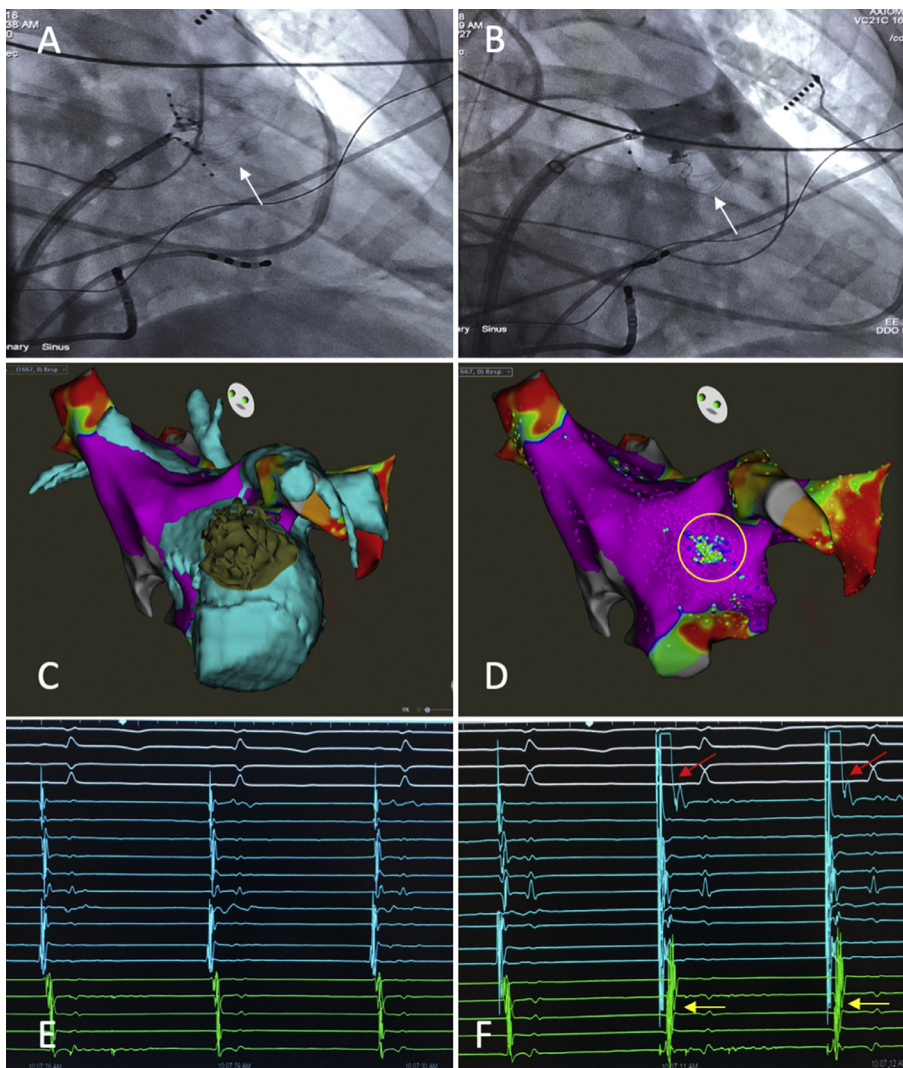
Patient 3. Panel A. Right anterior oblique view. Pentaray catheter splines over ostial surface of 27 mm Watchman device (white arrow) 167 days postimplant. Panel B. Right anterior oblique view. Contrast angiography of the left superior pulmonary vein after cryoballoon inflation. White arrow indicates Watchman device. Panel C. Fusion image of bipolar voltage map and preprocedure Cardiac CT imaging shows location of Watchman device in relation to left atrial and pulmonary vein anatomy acquired with 3D mapping. Panel D. High-density bipolar voltage map (0.05 to 0.5 mV) showing reduced voltage (<0.5 mV) mostly over the central surface of Watchman device. Yellow circular area indicates expected endocardial surface area of the Watchman device based upon CT fusion image. Panel E. Voltage recordings obtained with Pentaray catheter splines over the Watchman device. Panel F. Pacing from splines 1,2 with high amplitude recordings (red arrows) results in local capture and 1:1 capture of electrogram recordings on the decapolar catheter positioned in the coronary sinus (yellow arrows) at paced cycle length of 500 ms. (Color version of figure is available online.)
